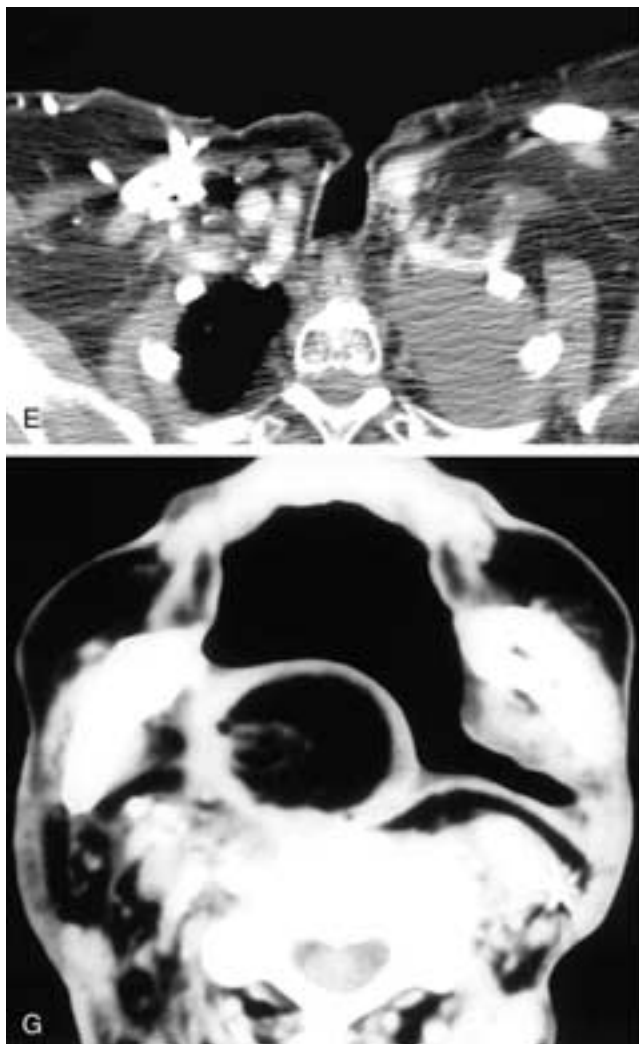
Continued.* In E through the lower neck, note the smooth, thin contours of the tracheostomy site. There is also incidental scarring of the left pleura. Axial contrast-enhanced CT scan (F) on a patient who has had a left partial pharyngectomy and a radical neck dissection with a myocutaneous flap reconstruction. Note the fatty appearance of the flap and the smooth contours of the margins of the flap. The flap also helps protect the carotid artery. Axial contrast-enhanced CT scan (G) on a patient who has had a pharyngectomy and a left radical neck dissection. Note the swirling minimal soft-tissue density within the bulk of the rotated flap and the smooth margins of the operative site. No soft-tissue nodularity is present.
